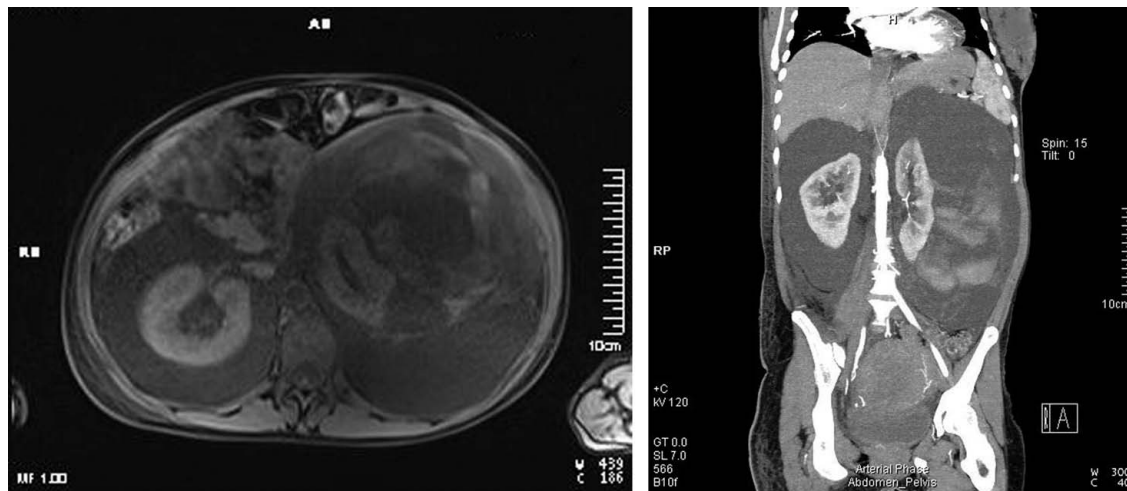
Computed tomography urogram reveals a mild decrease in the function of the left kidney.
